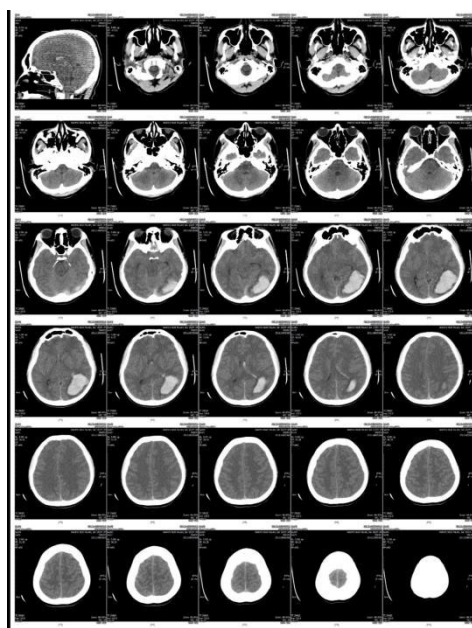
Initial Non-Contrast Brain CT Scan
